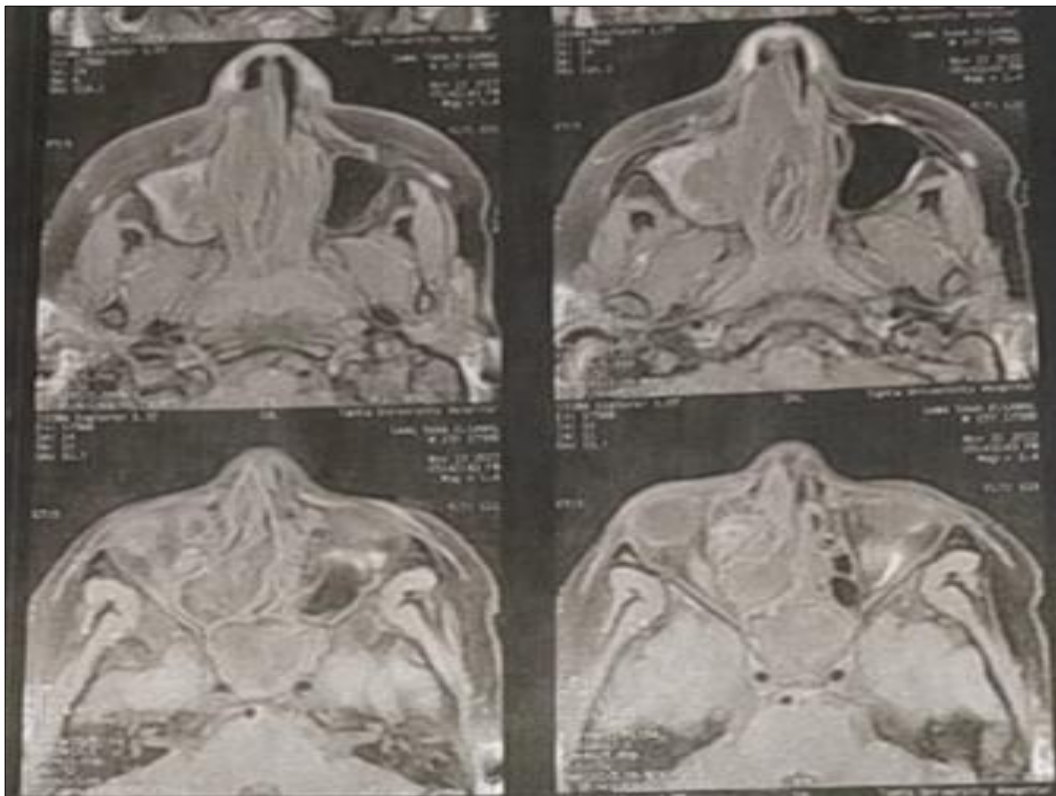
A male aged 70 y suffering from lost vision, complete ophthalmoplegia, severe headache and right facial gangrene following four weeks of COVID-19 infection with poorly controlled DM. Axial (A) T1, (B) T2 weighted MRI at level of nasopharynx showing a lesion occupying RT maxillary sinus, RT ant., post. Ethmoid sinus, sphenoid sinus and compressing the nasal septum
